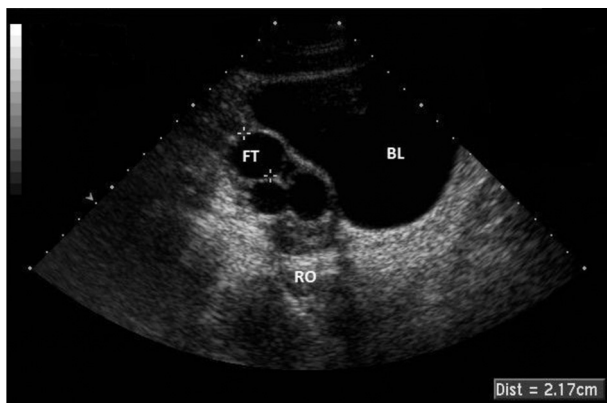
Pelvic ultrasound showing the dilated fallopian tube (FT). BL, bladder; RO, right ovary.
